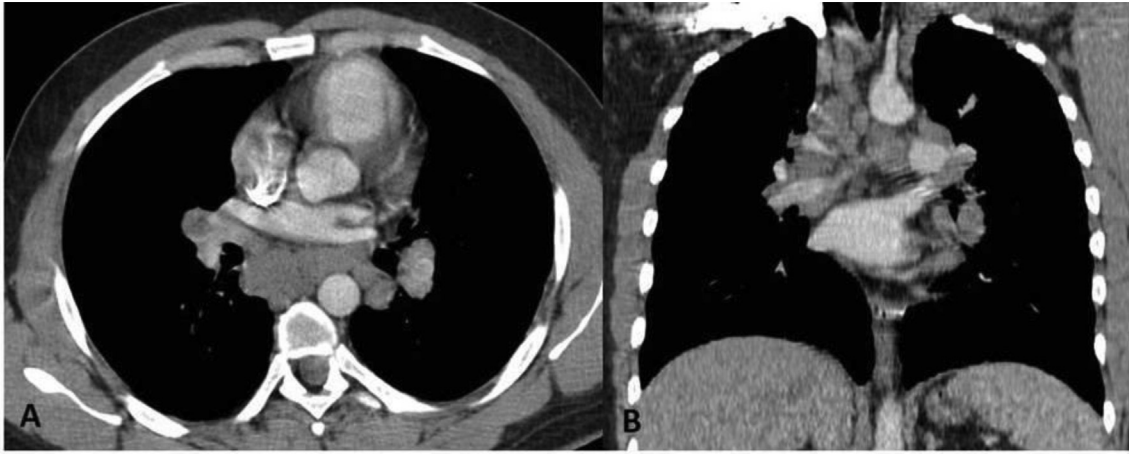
CT images from a 42-year-old woman presenting with chronic dyspnea. Axial (A) and coronal (B) reconstructions reveal pathologically enlarged mediastinal and hilar lymph nodes. A lymph node biopsy revealed sarcoidosis.
